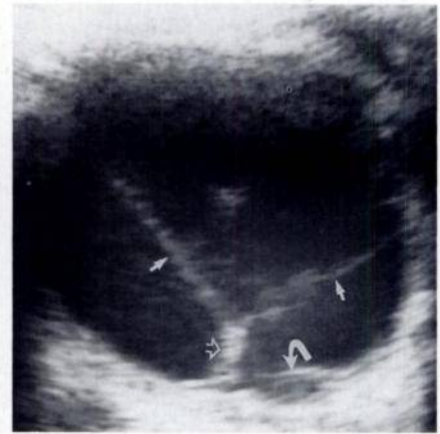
Chronic vitreous hemorrhage and detachment. Axial sonogram shows fibrous scar (*open arrow*) extending from detached vitreous (*solid straight arrows*) to posterior surface of globe. Scar has caused focal retinal detachment (*curved arrow*). Small subretinal hematoma also is visible.
